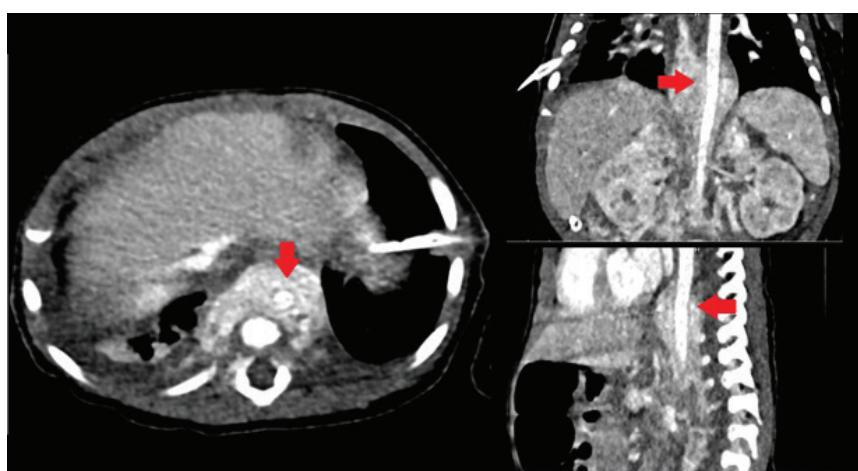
Contrast-enhanced CT of the chest and abdomen – revealed para-aortic mass
